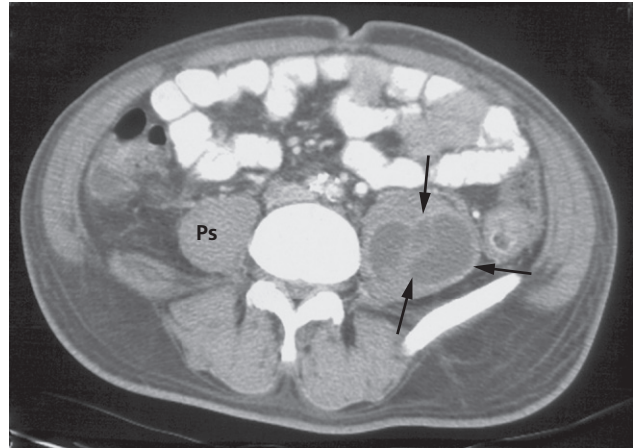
Psoas abscess. CT scan showing a left psoas abscess (arrows). Note the thick wall, which has a rim of enhancement, and low density, fluid-like contents. Ps, normal right psoas muscle.
